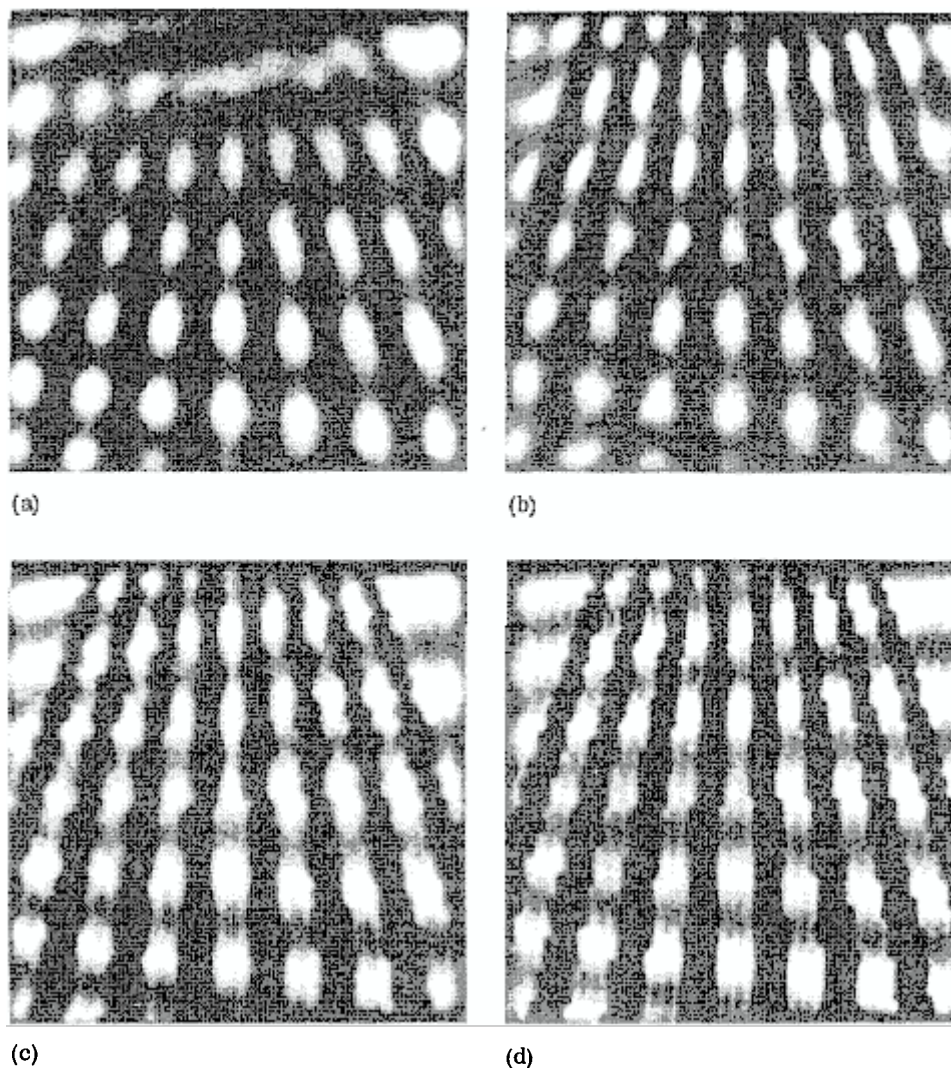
Results of filtering the radiograph in Fig. 12a with digital tomographic filters. Filters designed to recover the layer farthest away from the film: (a) filter with minimum gain of 10 dB; (b) filter with maximum gain of 20 dB. Filters designed to recover the layer closest to the film: (c) filter with maximum gain of 20 dB; (d) filter with maximum gain of 40 dB.
